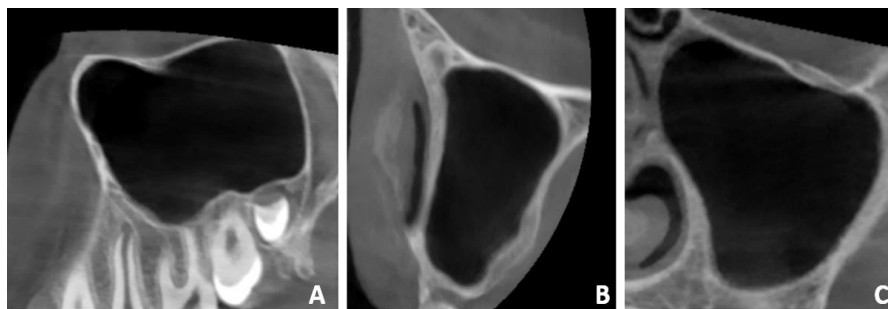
CBCT images in multiple planes showing fully aerated maxillary sinuses with intact bony walls and no evidence of mucosal thickening, fluid accumulation, or other pathology.
